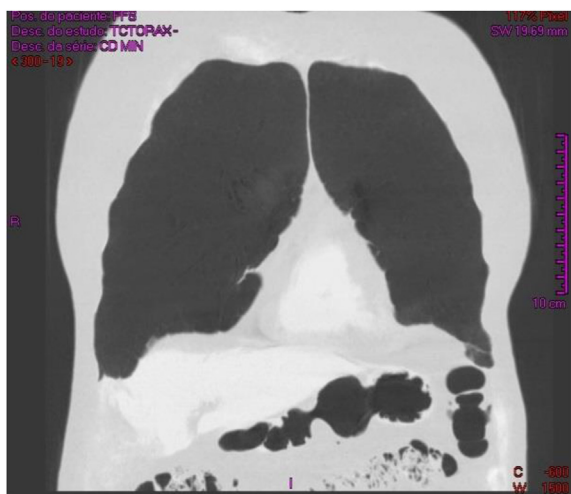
CT image showing centrilobular nodular opacities in the left lower lobe and facial glass nodular opacities in the apicoposterior segment of the upper left lobe. Small, sparse non-calcified nodular opacities < 0.03cm present bilaterally.
